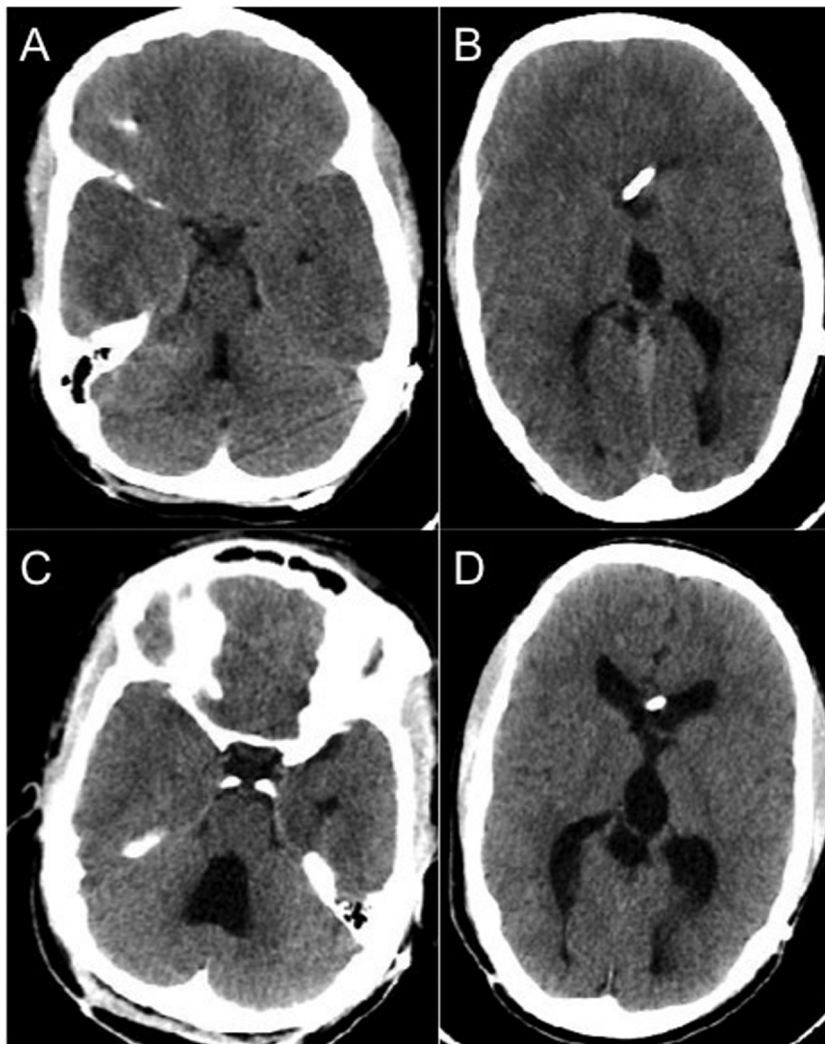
Previous CT Head without contrast from four years prior to presentation (A, B). CT Head without contrast at presentation showing hydrocephalus (C, D).
